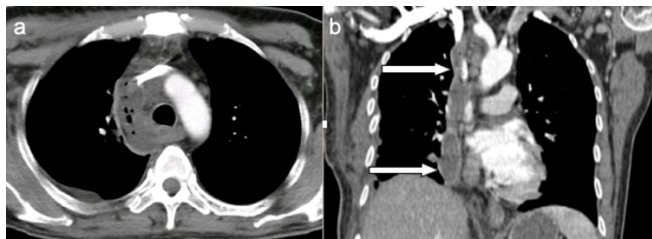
Axial (a) and coronal (b) contrast enhanced CT images showing a mediastinal abscess (arrow) at the right paratracheal area in superior mediastinum extending through mediastinum to the right hemidiaphragm.
